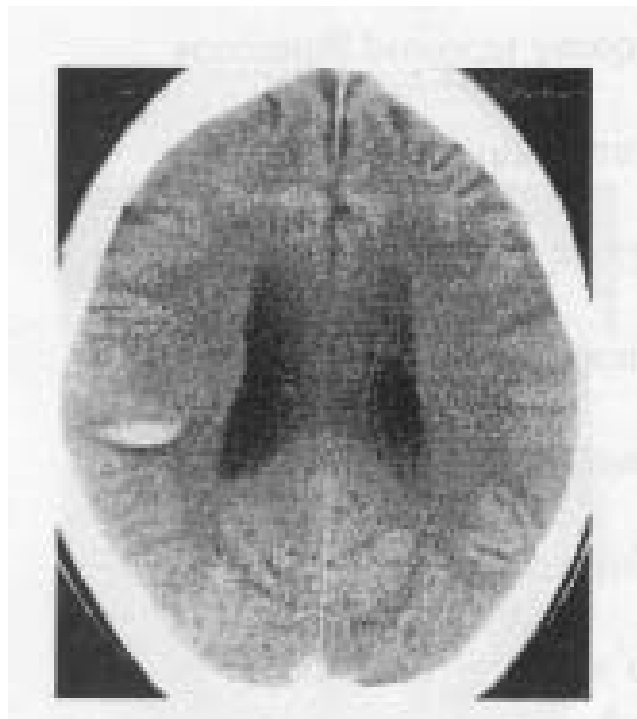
Noncontrast axial head CT scan shows a subcortical hemorrhagic venous infarct in the right parietal region in a patient with a dense triangle or delta sign.
